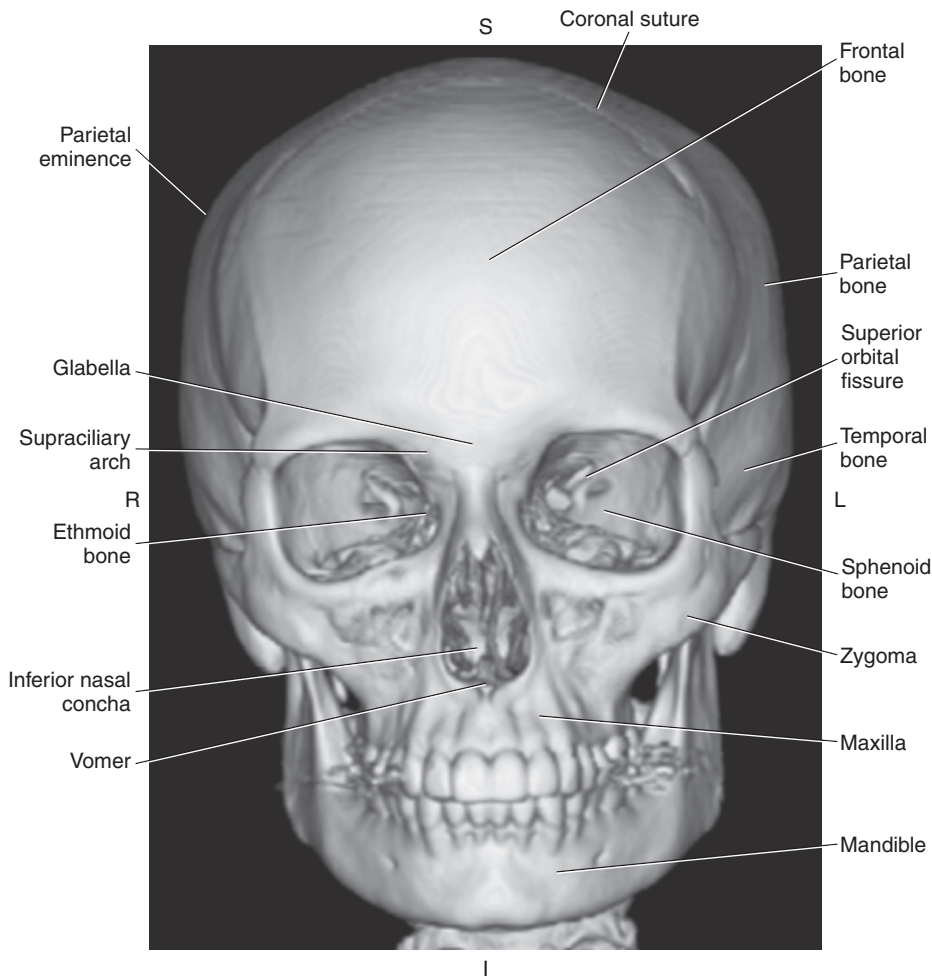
3D CT of anterior skull.
